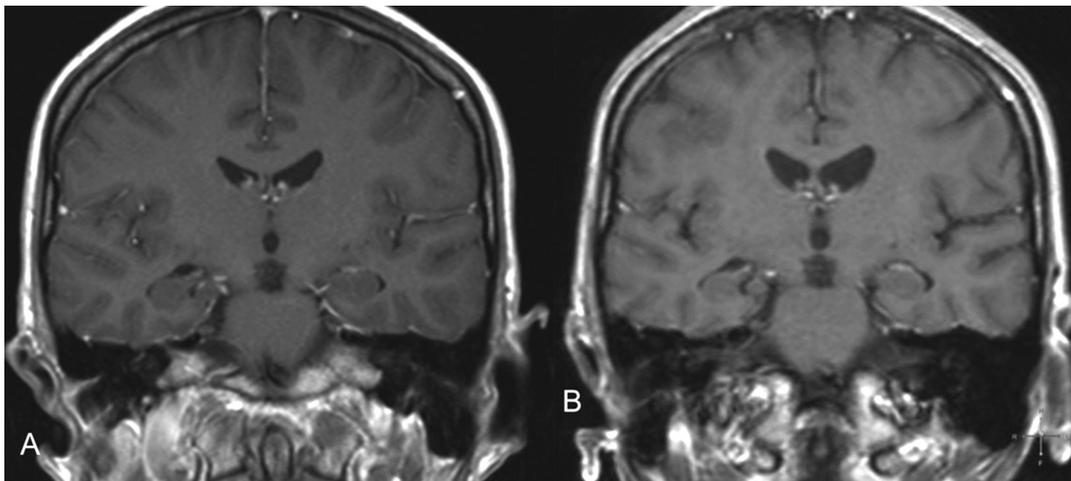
Coronal view sections at the level of the third ventricle and hippocampal formation in the patient: A – 2007, B – 2011. MRI scans show progressive atrophy of the caudate nuclei (mainly of the left one), the right hippocampus and the whole brain
